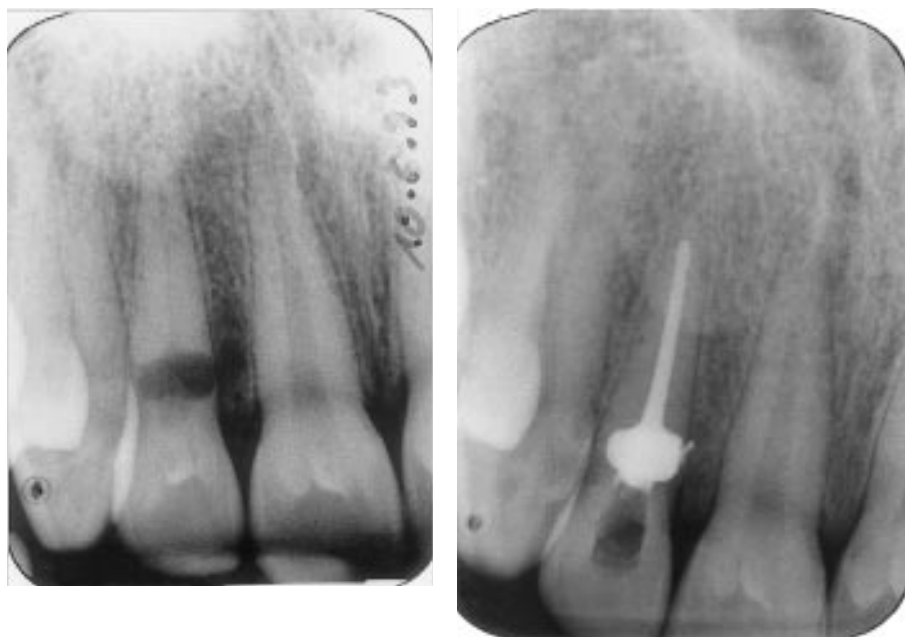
(a) Right maxillary lateral incisor in the same patient as in Fig. 5. The invagination was detected by preventive radiographic examination, clinically no invagination nor carious lesion were detected. The invagination has resulted in an internal resorption with perforation. (b) Obturation with injectable gutta-percha, resulting in a slight lateral overfill.
